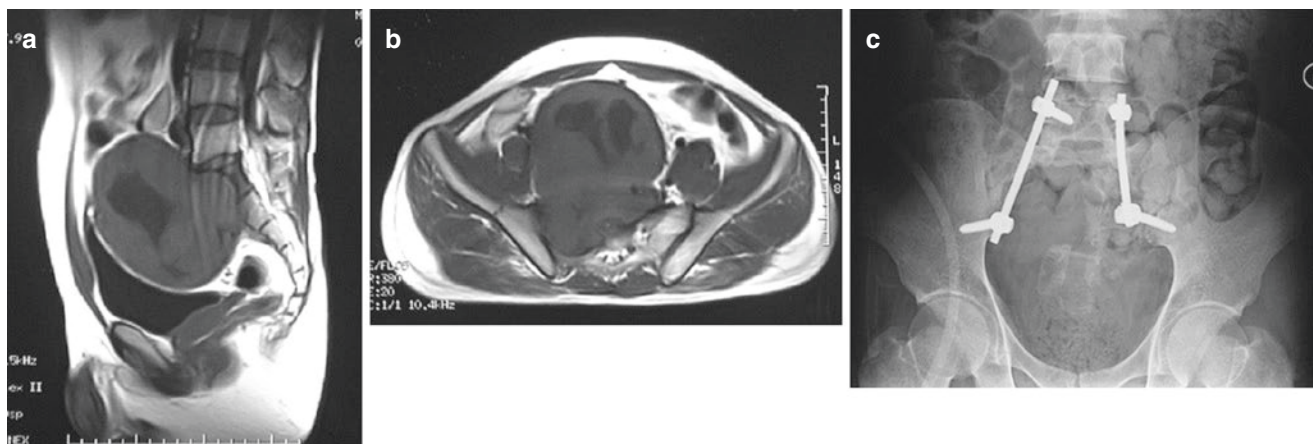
The MRI showed a huge schwannoma (type II) located anterior to sacrum and involving the S1 vertebral body, with the upper limit reaching the upper margin of L5 (a and b). The radiograph plain (c) film
